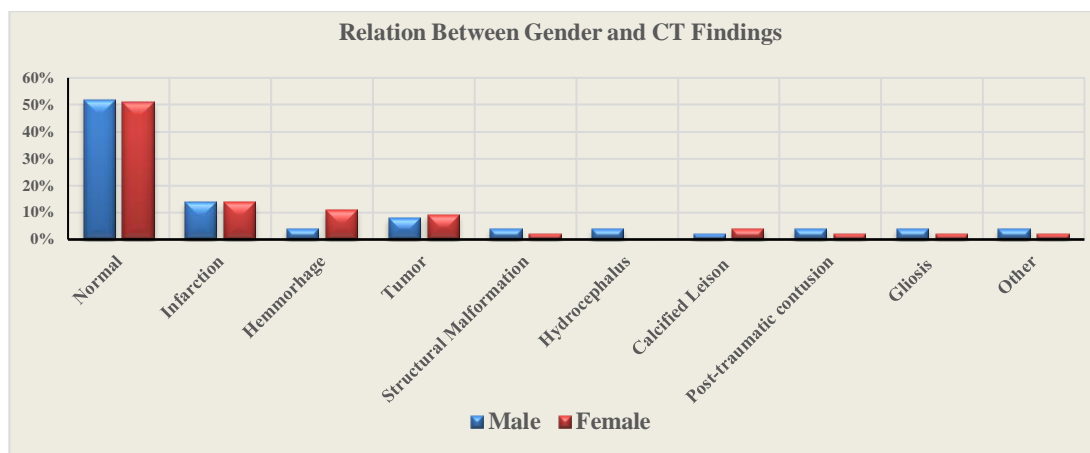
Relation between Gender and CT findings (n = 93) (insignificant, P value = 0.732)
